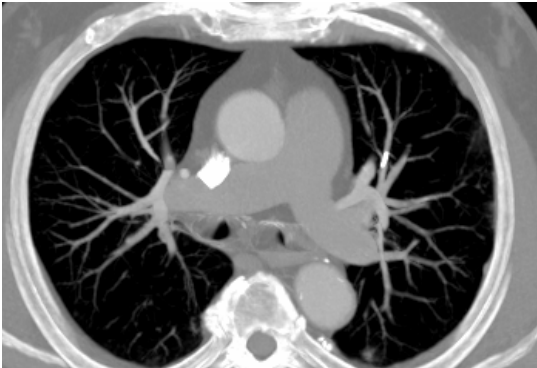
CT scan showing the solitary cement-embolus in the left pulmonary artery.
